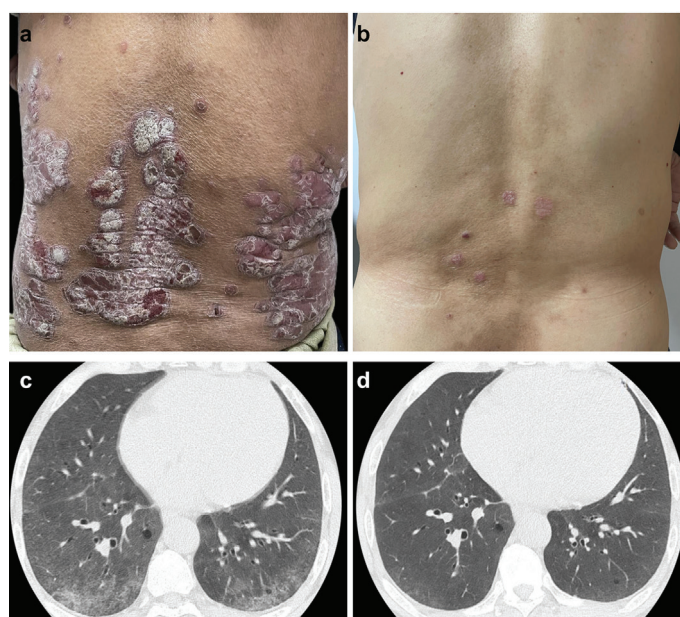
Clinical and chest computed tomography (CT) course. (a) Multiple scaly erythematous plaques on the trunk. (b) Psoriatic plaques were mostly eliminated 1 year after secukinumab administration. (c) High resolution CT of the chest 1 year after the initiation of secukinumab therapy showing diffuse lamellar hyperdense shadows in both lungs, with multiple mesenchymal changes in the subpleural. (d) 10 months after the cessation of secukinumab therapy.
